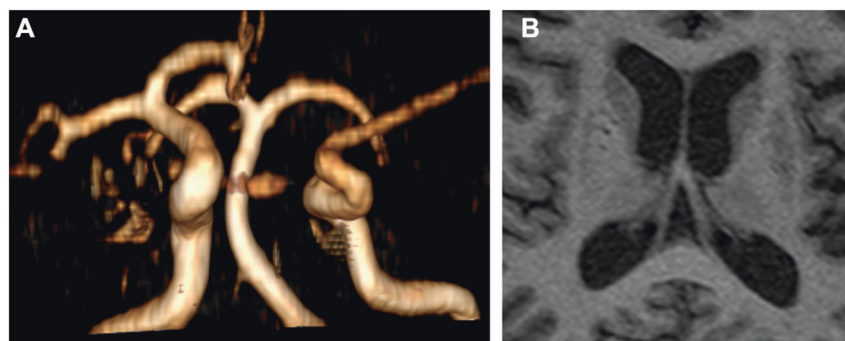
In panel a, the right anterior and middle cerebral arteries seem dilated, possibly in relationship to compensatory changes given the absence of a contralateral first segment of the anterior cerebral artery. The brain MRI shows evidence of dilated perivascular spaces in the basal ganglia, more demarcated in the right caudate and anterior
